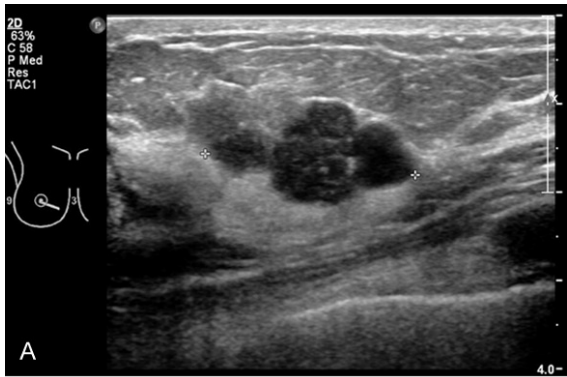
(A) Breast ultrasonography showed a multi-lobulating mixed hypoechoic and isoechoic mass measuring 2.9 cm in size at the periareolar area. (B) F-18 fluorodeoxyglucose (FDG) positron emission tomography/magnetic resonance imaging (PET/MRI)-mammography and (C) the second post-contrast subtraction series of dynamic T1 weighted breast MRI demonstrated an irregularly shaped mass with increased F-18 FDG uptake.
